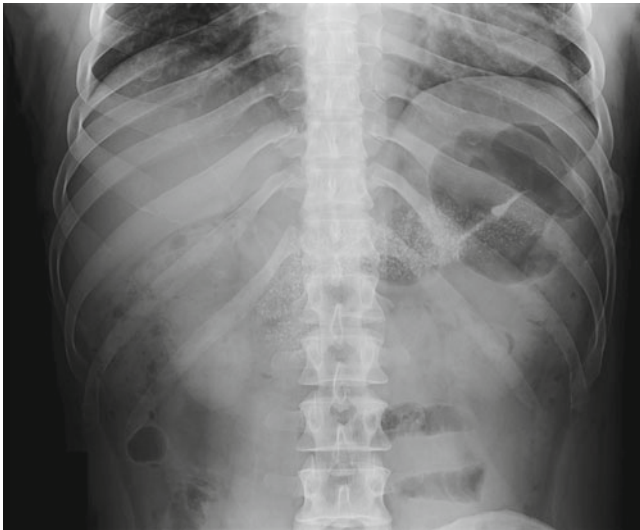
Abdominal plain film in a patient with chronic pancreatitis with diffuse calcifications in the pancreas
